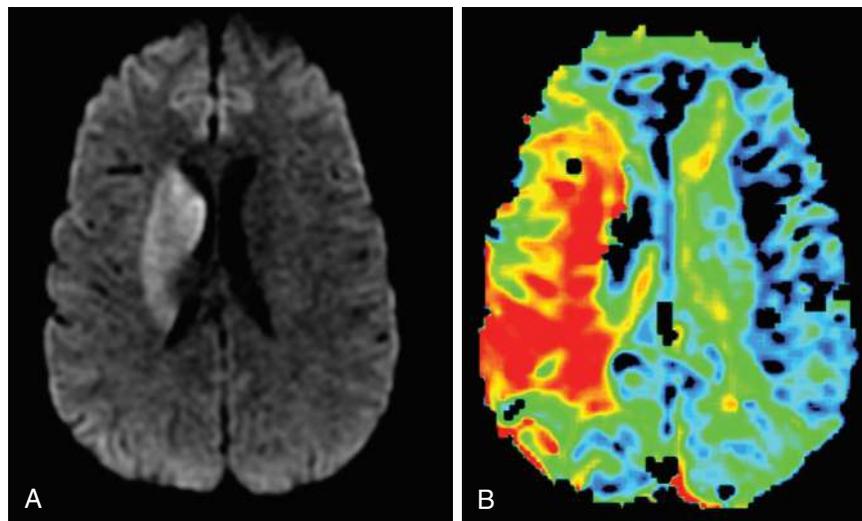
Magnetic Resonance Imaging of the Same Patient in Fig. 46.2. A, Diffusion-weighted imaging (DWI) showing right basal ganglia stroke. B, Perfusion-weighted imaging (PWI) showing enhanced mean time to enhancement. These sequences together suggest a large ischemic penumbra in the right middle cerebral artery (MCA) territory.
